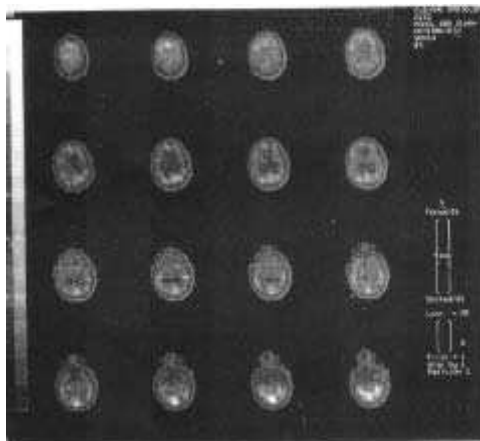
Transaxial view of the brain, normal cerebral SPECT scan
